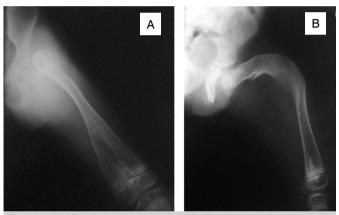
A) AP radiograph of the left thigh of a nine-year-old patient with OI and extreme varus of the proximal femur and bone overlap. B) Lateral radiograph of the same patient showing the flexion deformity.
